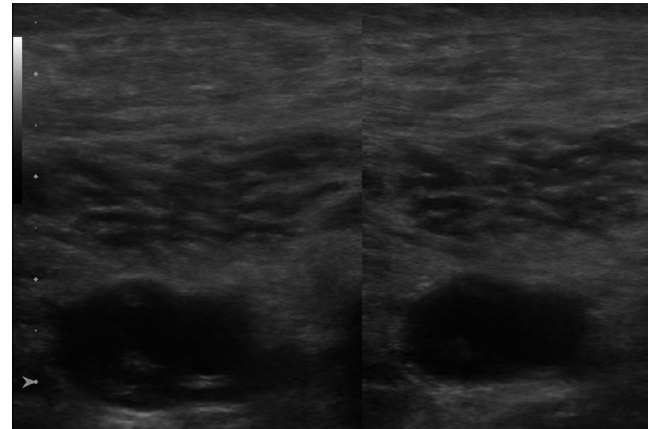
Ultrasound of the right distal vena poplitea (no compression possible), Department of Internal Medicine I, Angiology. Clinical question: In case of an obstruction of the drainage via the V. Cava inferior, the question of a consecutive leg vein thrombosis arose. The compression test in sonography revealed a thrombosis of the right popliteal vein
